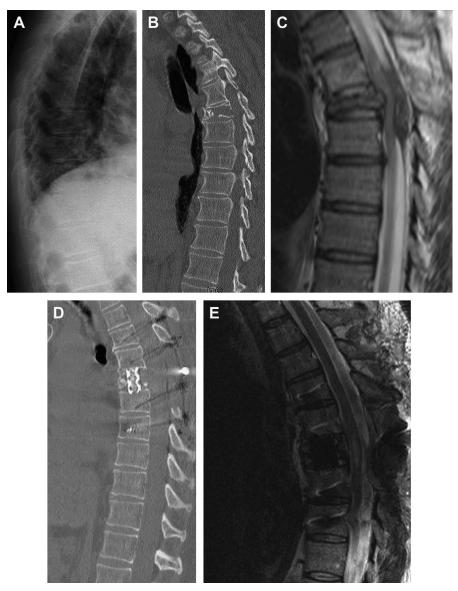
(A) Plain X-rays raised suspicion of a fracture of T6. (B) Computed tomography (CT) confirmed the fracture of T6 suggesting a hemangioma. (C) Magnetic resonance imaging (MRI) demonstrated an extensive lesion within T6 with intrusion into the spinal canal, spinal cord compression with beginning cord edema. (D and E) Control CT scans and MRI showed no evidence of hematoma or myelon compression but a progressive spinal cord edema.
